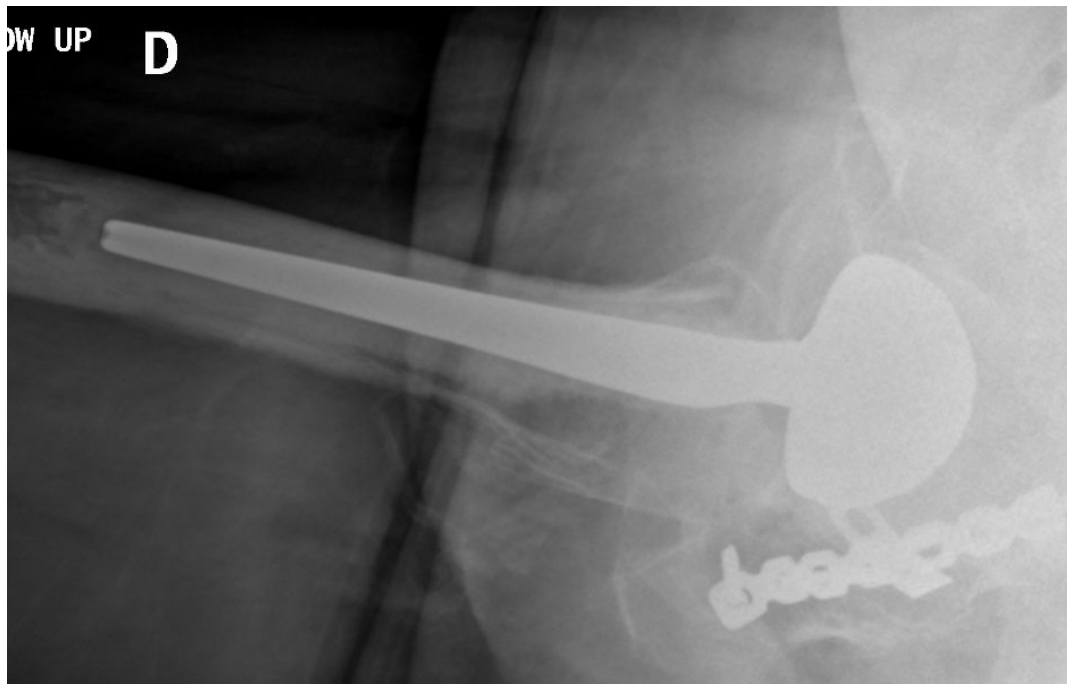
a) Antero-posterior pelvis radiograph of an 82-year-old man with severe post-traumatic right hip osteoarthritis. The fracture and secondary degeneration modified the orientation of the native acetabular cavity. Use of a DM LDH THA helped to obtain a stable joint and may tolerate potential surgical imprecision;
